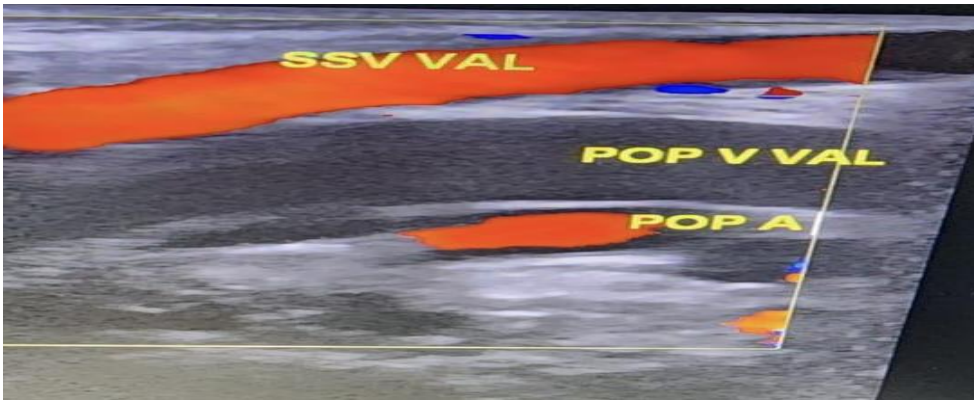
Color doppler ultrasound at the level of the popliteal vein showing maintained flow in the small saphenous vein (SSV) during valsalva maneuver.
